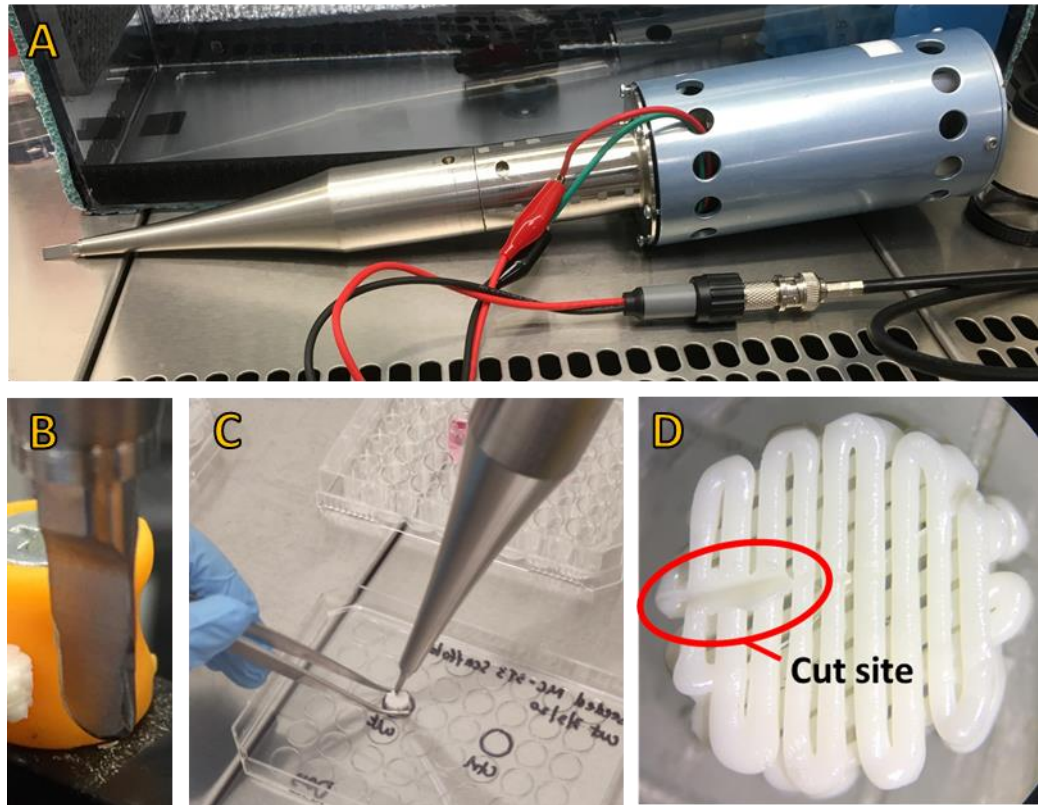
Ultrasonic cutting of 3D scaffolds seeded with MC3T3-E1 cells. A & B: the cutting tool. C: Cutting a scaffold. D: Cut site under magnification (unseeded). Localised melting leaves ridges of material either side of cut site.
